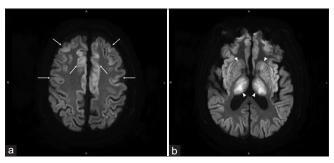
(a) Brain magnetic resonance imaging showing symmetrical and diffuse water diffusion restriction at the deep and superficial gray matter, including the bilateral cerebral cortex, cingulate gyrus, and insular cortex (arrow). (b) Basal ganglia and thalamus (arrowhead) on diffusion-weighted imaging
